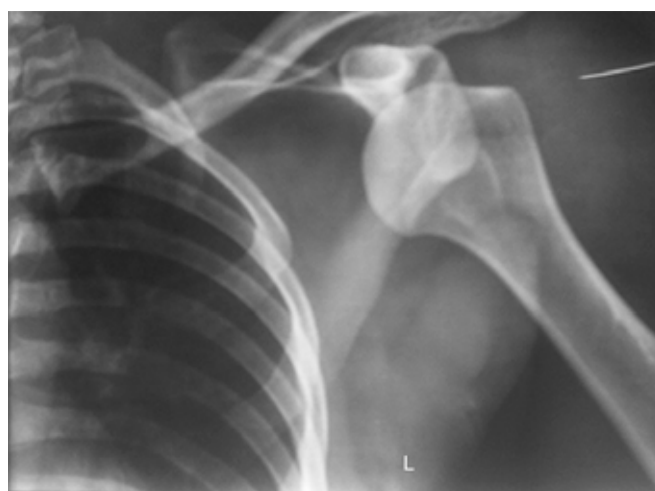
Anteroposterior X-ray of shoulder showing anterior shoulder dislocation.
